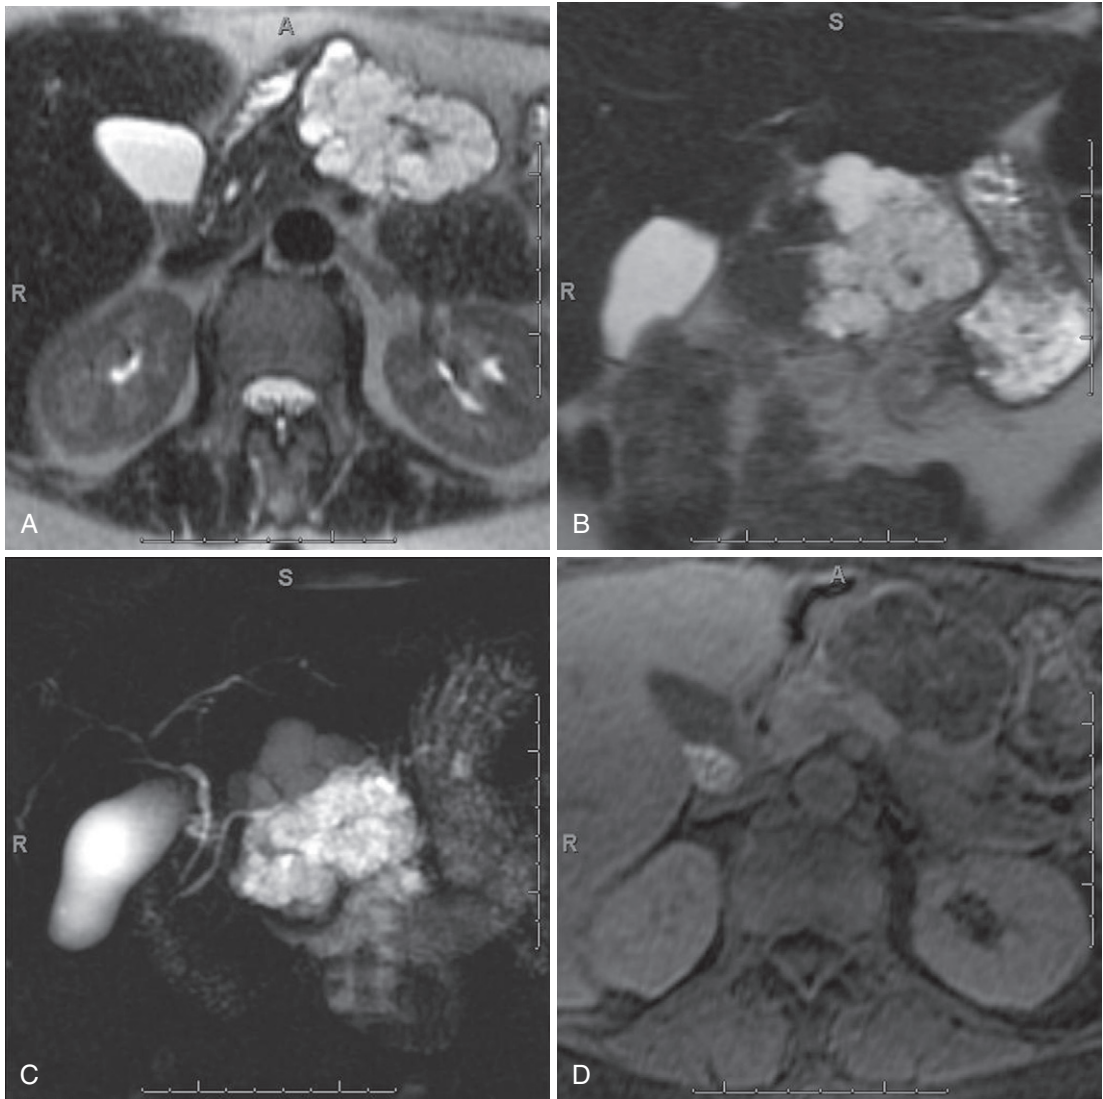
Pancreatic serous cystadenoma. Axial (A) and coronal (B) T2-weighted, coronal thick-slab MRCP (C), and dynamic pre-contrast (D), early arterial (E), late arterial (F), and delayed (G) 3-D fat-suppressed T1-weighted gradient recalled-echo images depict a large multiloculated cystic lesion in the distal body of the pancreas with minimal enhancement of the septations, in keeping with a pancreatic serous cystadenoma.
